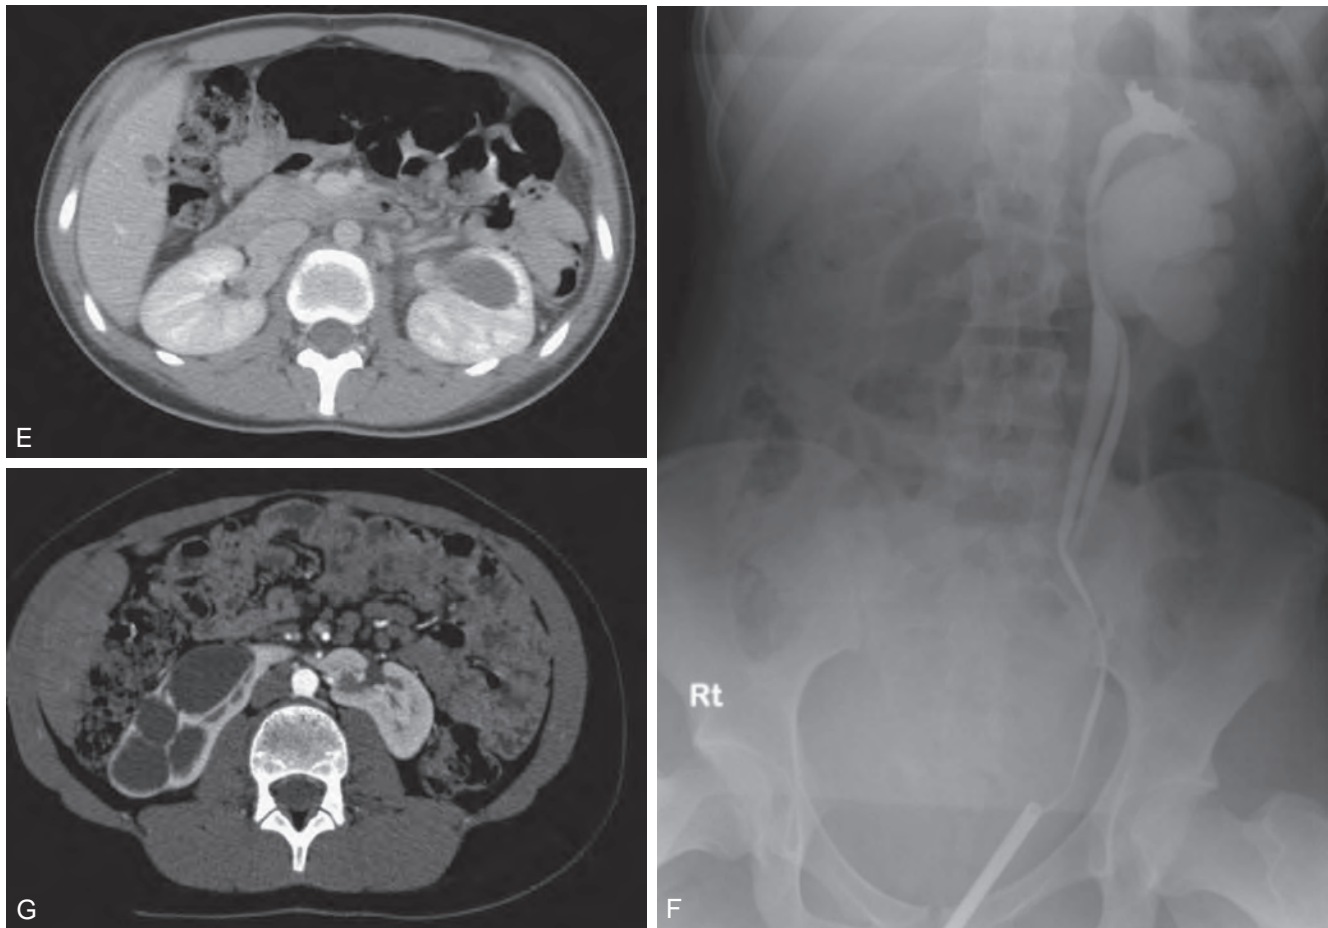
cont'd E, A 15-year-old boy presented with gross hematuria following a fall while running in a cross-country race; findings were suggestive of left lower pole UPJ obstruction. F, Left retrograde pyelogram confirmed incomplete left duplication with left lower pole UPJ obstruction. G, A 14-year-old male presented with gross hematuria following a collision while playing hockey. CT scan revealed horseshoe kidney with severe right UPJ obstruction.
